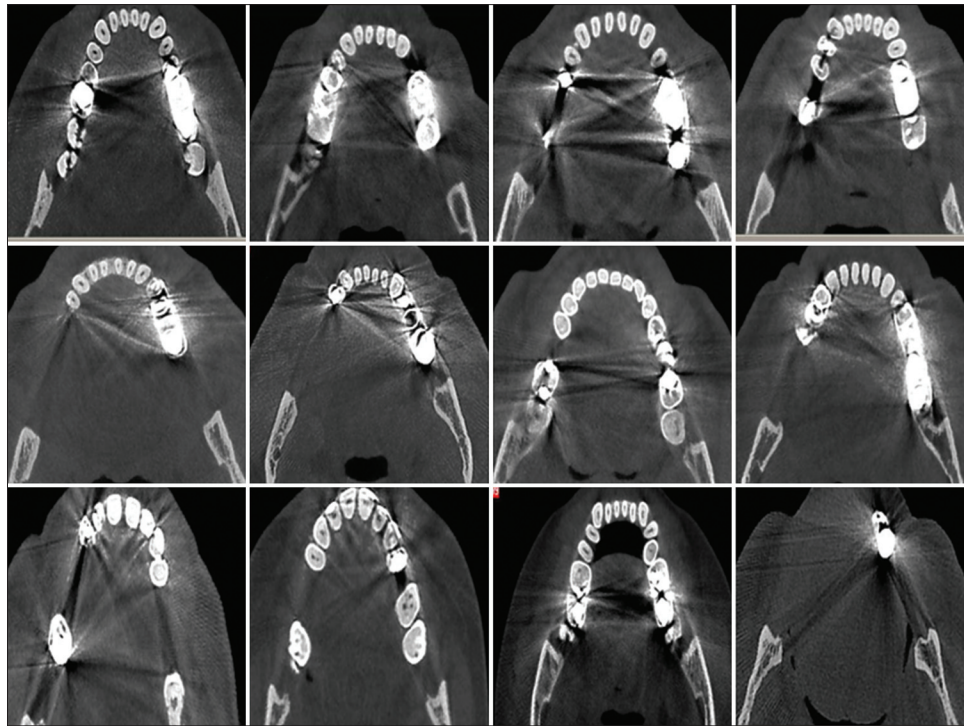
Dental cone beam computed tomography images for artifact reduction
